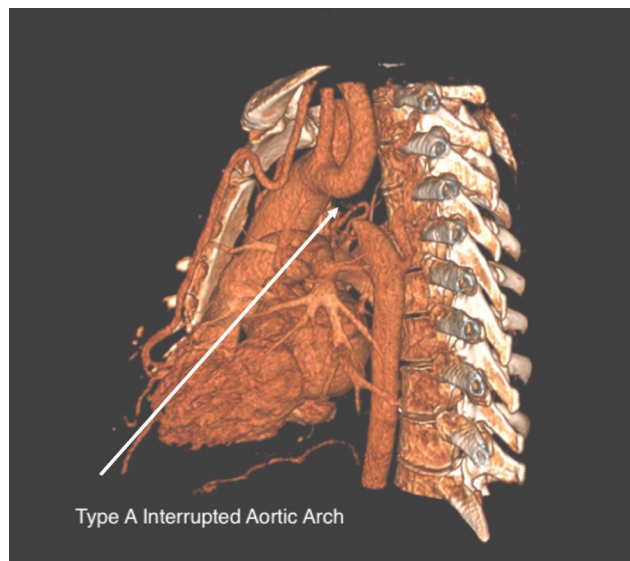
Preoperative computed tomography reconstruction of Type A interrupted aortic arch.
